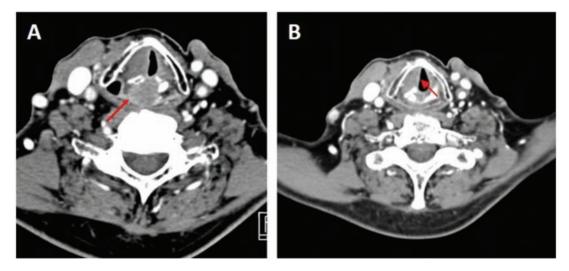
Retrocricoid carcinoma and narrowing of the glottis after radiotherapy. (A) CT scan performed before surgery and before radiotherapy showing a carcinoma located in the posterior commissure (red arrow). (B) CT scan performed after surgery and after radiotherapy (when the patient developed stridor during sleep). The tumor was removed but the right vocal cord is fixed in the middline and the glottic space is reduced (red arrow).
